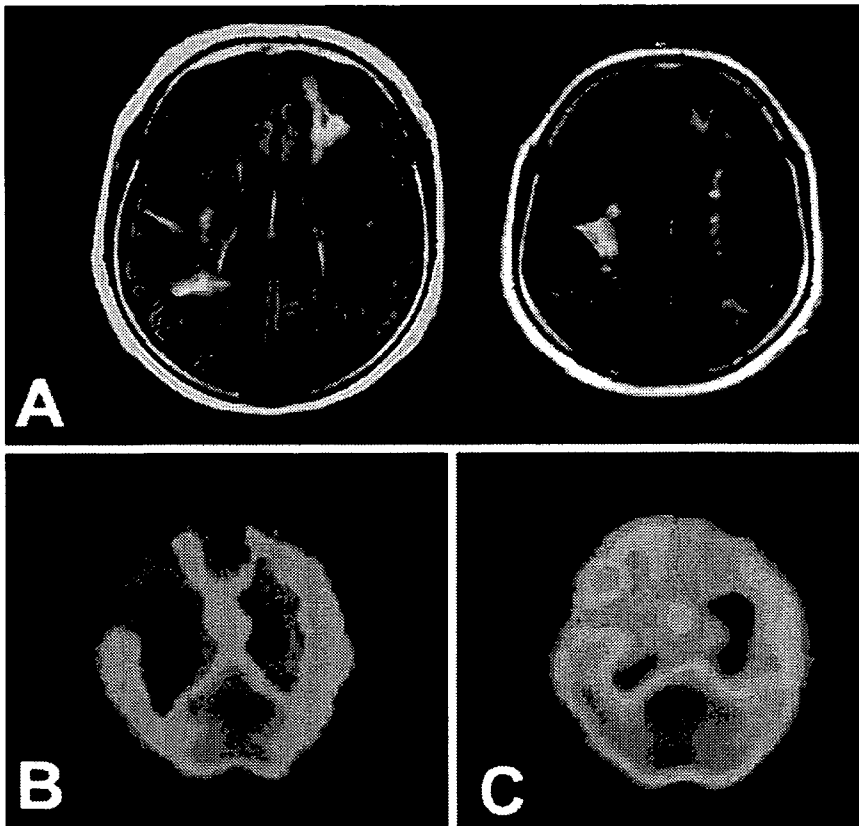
Radiological findings of a 65-year-old woman with asymptomatic moyamoya disease. Note multiple cerebral infarctions in both hemispheres on MRI (A) and reduction of cerebral blood flow and its reactivity to acetazolamide on single photon emission tomography before (B) and after intravenous injection of acetazolamide (C).
